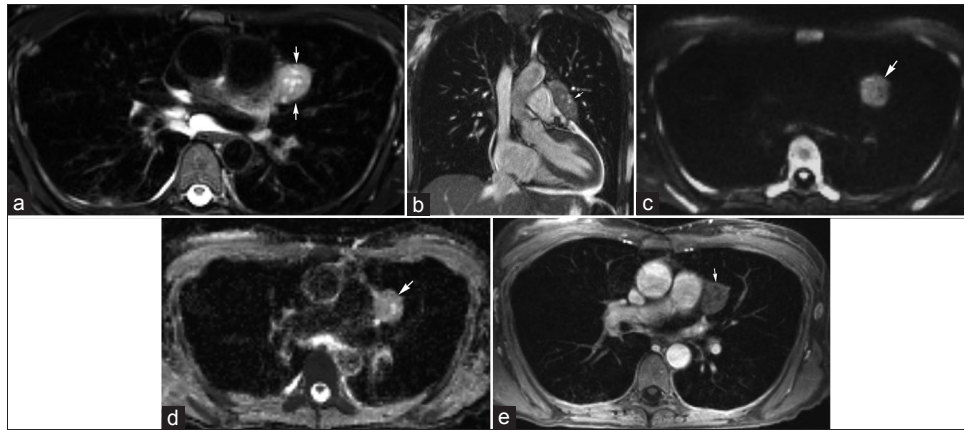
A 45-year-old female with chronic upper respiratory symptoms and dry cough. (a) Axial T2-weighted image and (b) coronal bSSFP image demonstrate an elongated rounded mass (arrows) with internal cystic areas along the course of the left phrenic nerve. (c) Diffusion-weighted image using $b=800$ s/mm² and correlating (d) apparent diffusion coefficient (ADC) map show no appreciable restricted diffusion (arrow). (e) Contrast-enhanced axial image demonstrates minimal enhancement of this mass (arrow). Differential considerations include thymoma and left phrenic nerve sheath tumor. The mass was resected with pathology indicating a thymoma with extensive cystic change.
